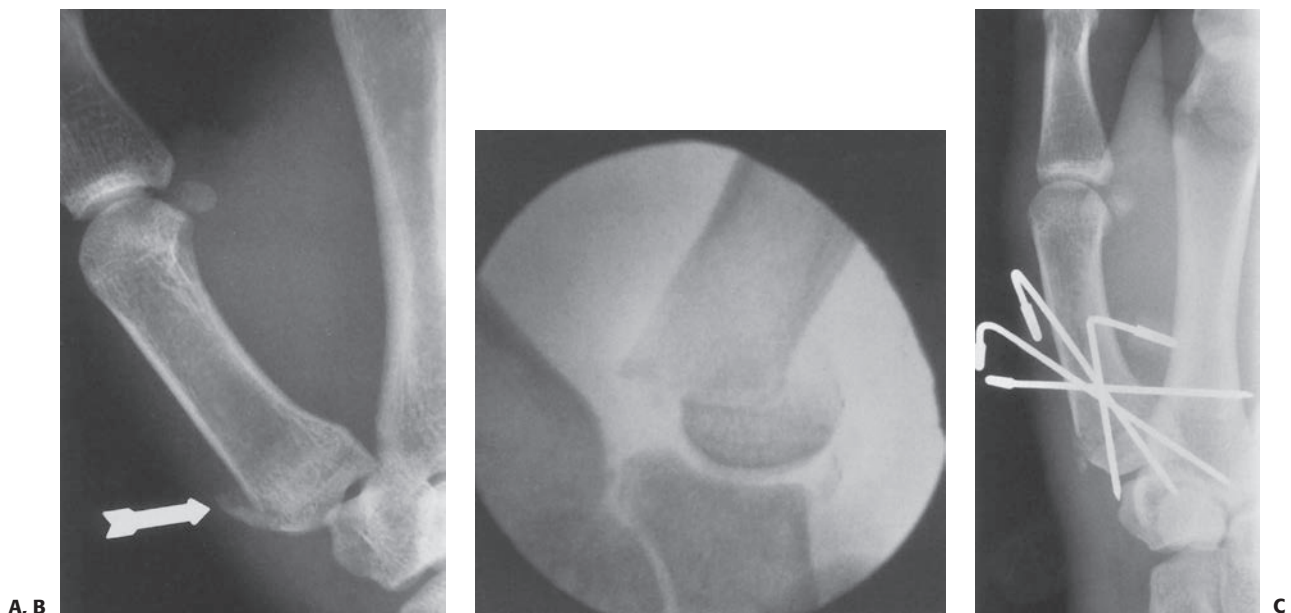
A: Fracture of the thumb metacarpal base with small lateral metaphyseal flag that appears innocuous on radiograph (*arrow*). B: However, additional images revealed marked displacement of the distal fragment. C: Closed reduction was unsuccessful, because of interposed tissue. After open reduction, K-wires were used to stabilize the fracture.
